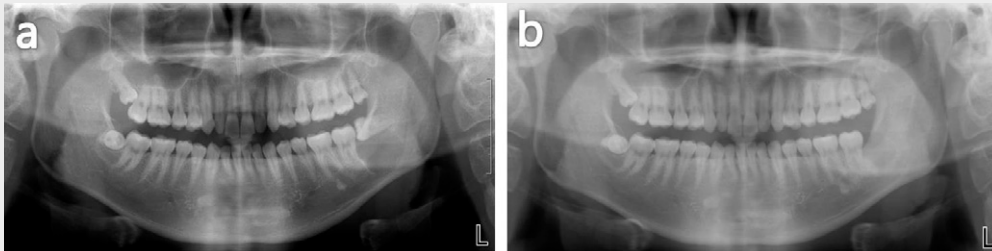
Panoramic X-rays of case 3.
